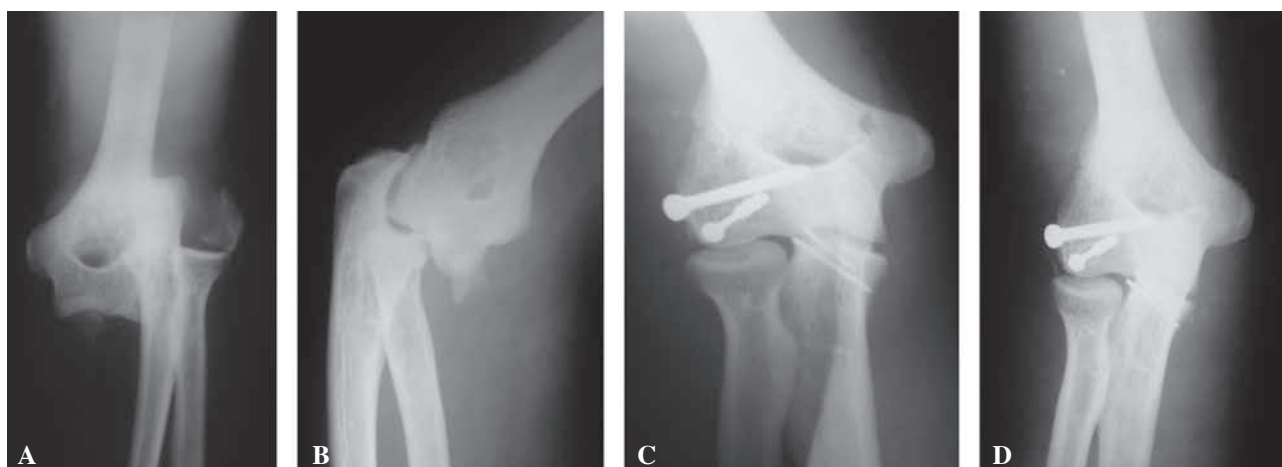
Patient 3. Fracture-dislocation of the humeral condyle (AO-Type-B1.1 and fracture of the coronoid process/Postero-lateral elbow dislocation). (A, B). Pre-operative radiographs ; (C). After surgery. (D). Radiographs at 12-month follow-up.
